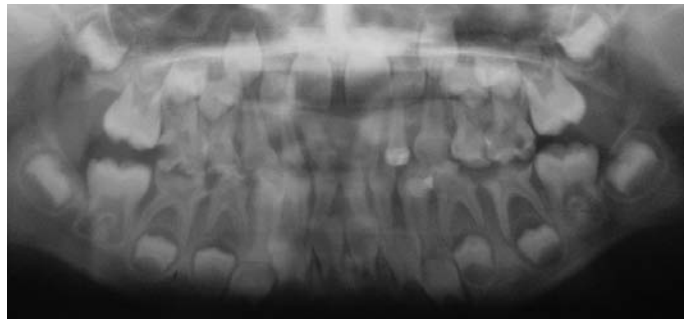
Panoramic radiograph of the female patient. No sign of alveolar bone resorption was evident.
